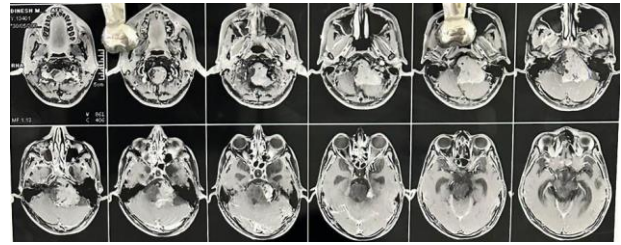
MRI brain, T1 contrast, axial images.
